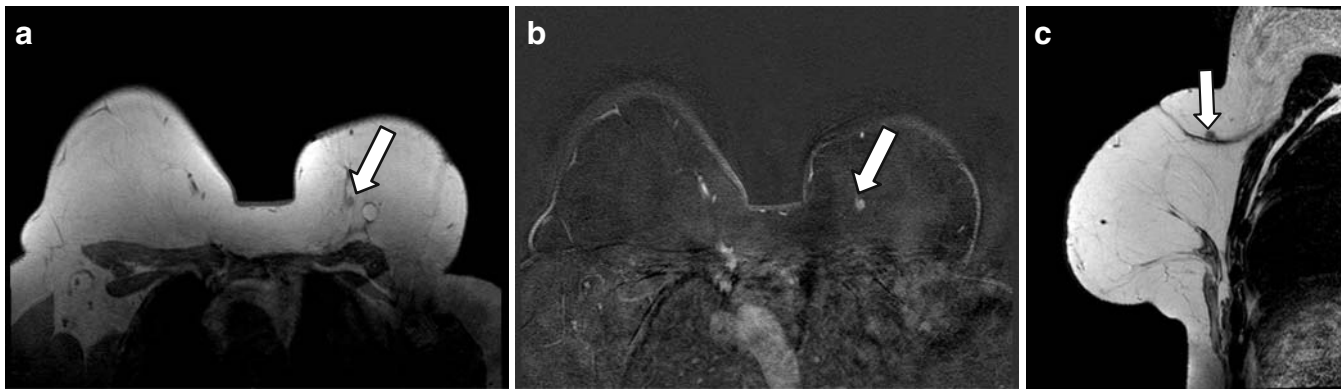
Case number 8861 of April 20th, 2009; 37 year-old patient, left radical mastectomy in 2003 and breast reconstruction with TRAM flap in 2004; dynamic study before the Gadolinium injection (A), subtraction (B) in the transverse plan and T2-weighted sequence in the sagittal plan (C) showing an enhancement mass away from the flap, confirmed as fat necrosis (white arrows); note the atypical pattern of the fat necrosis without central fat tissue representing pitfall.
